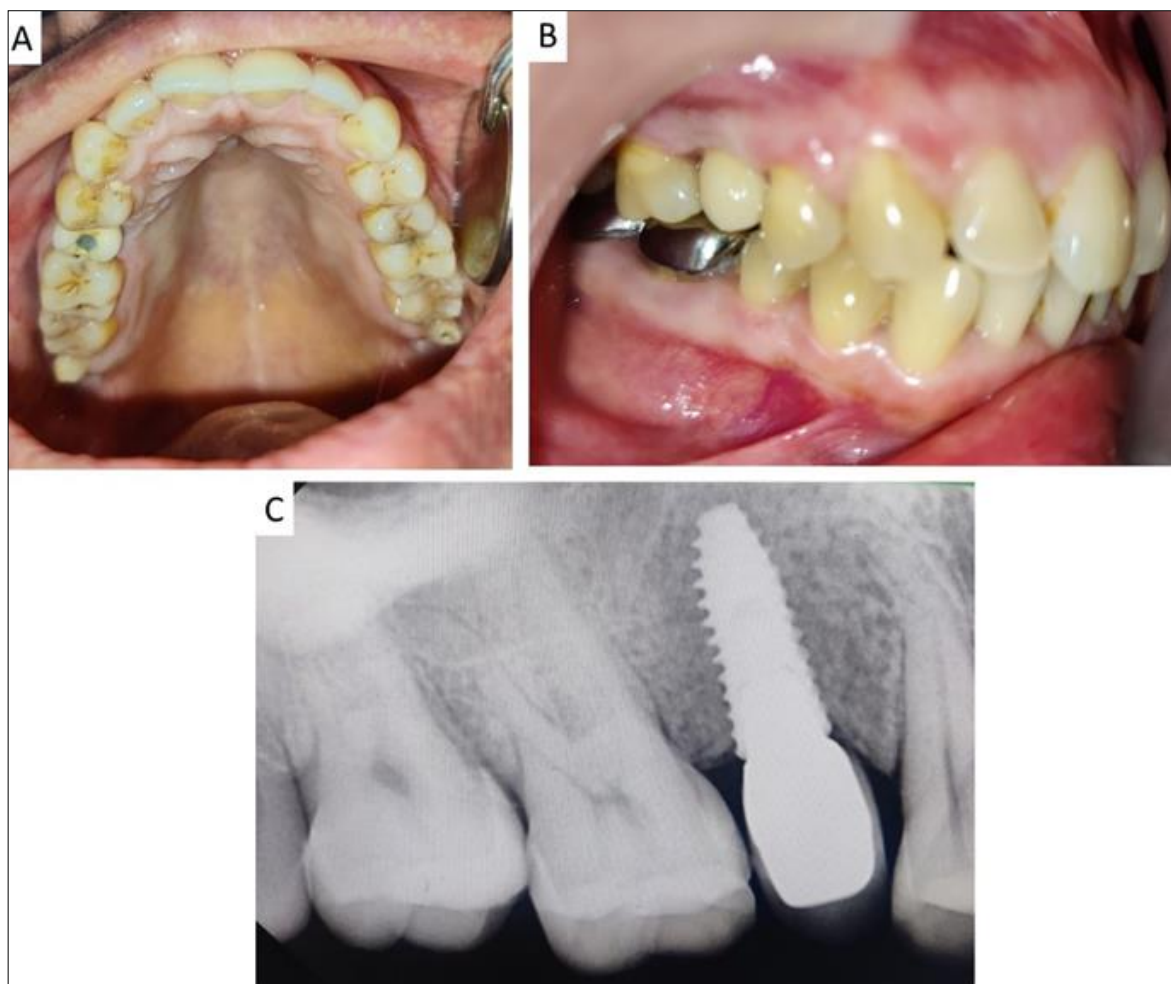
A) Implant loaded with screw-retained porcelain fused to metal crown, B) Achieved occlusion with the prosthesis in place; C) intra-oral periapical radiograph after placement of the prosthesis
